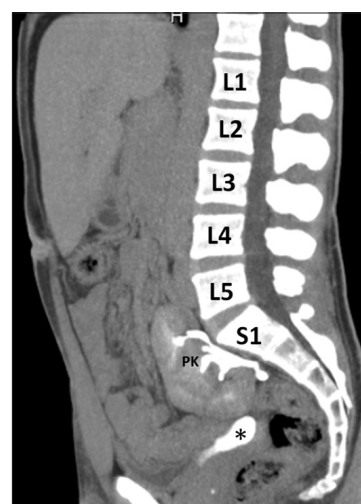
The sagittal section of the computed tomography urogram demonstrating the left kidney, which is located at the top of the bladder. *: Urinary bladder
